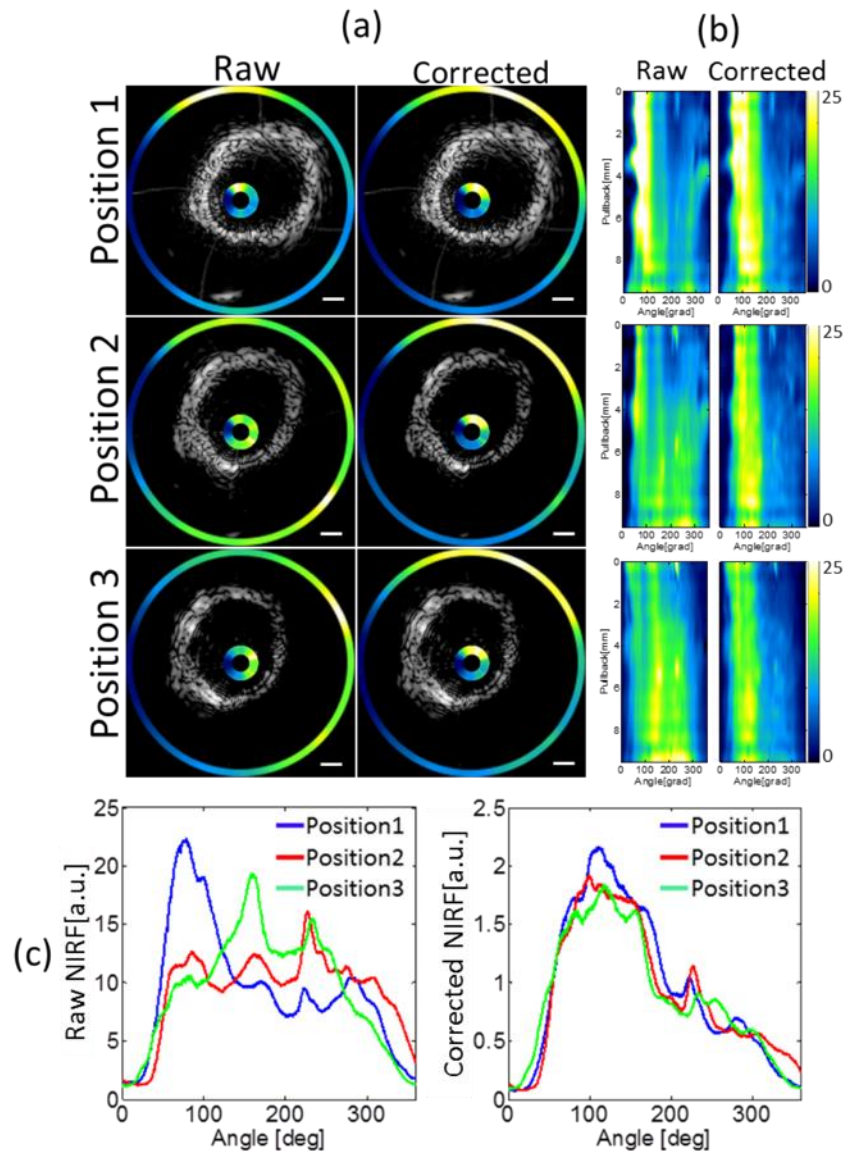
Results of ex vivo imaging experiments in the abdominal aorta of a rabbit following AF750 NIR fluorophore injected into the artery wall. (a) Three imaging sessions of the same region of the vessel were performed with catheter placed in different intraluminal positions. Representative ultrasound image of the vessel cross section obtained from each position is presented in black and white colors. Each colored circular ring represents corresponding raw NIRF or corrected NIRF signals, and are depicted on the interior of the IVUS catheter, as well as externally around the vessel wall. (b) Representation of the raw and corrected NIRF two-dimensional images obtained in different intraluminal positions. (c) Comparison between raw and corrected 1D NIRF signals. All scale bars 1mm.
